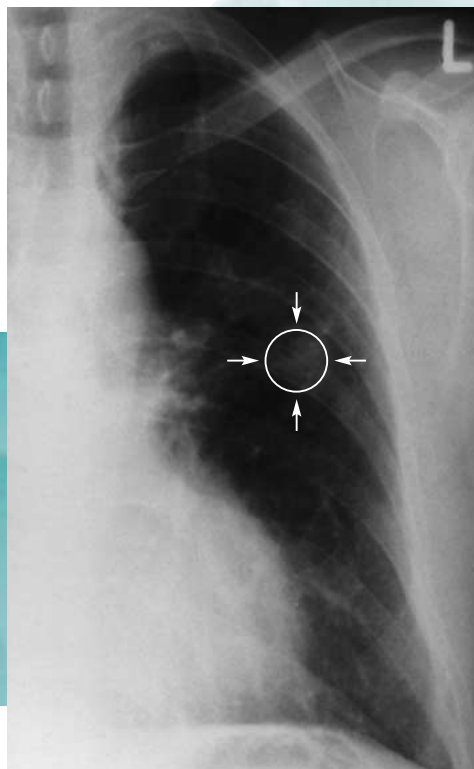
Aspergilloma (see arrow) caused by *A. fumigatus* in a 43-year-old patient. Chest X-ray.
